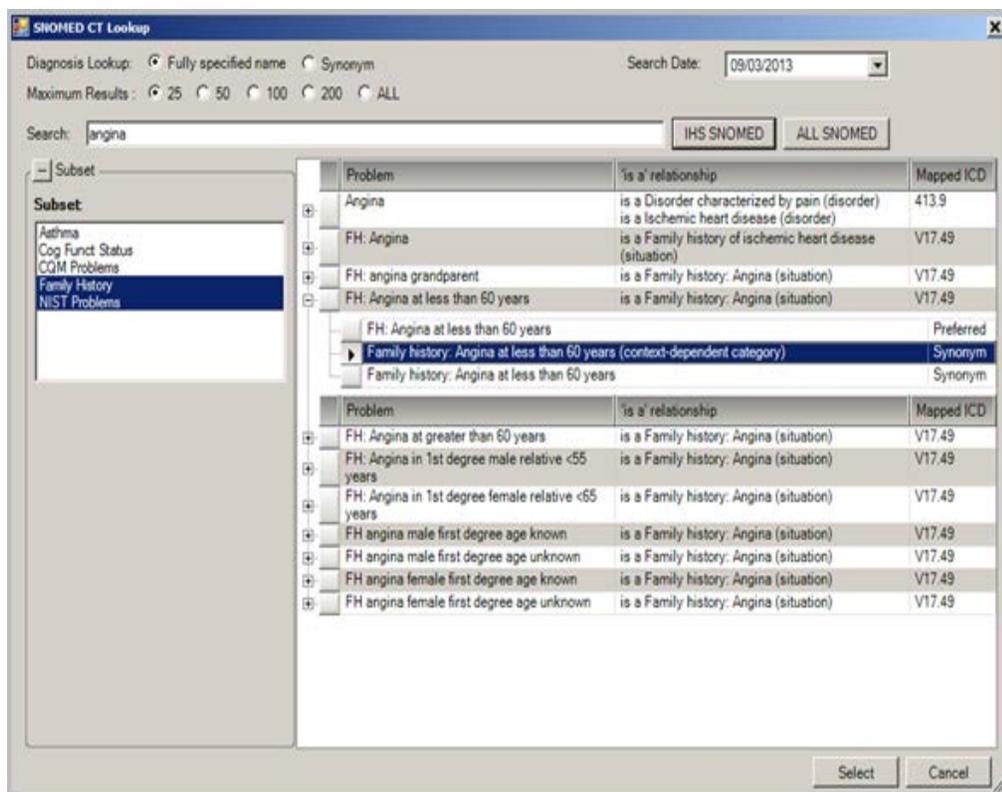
Lookup SNOMED CT dialog
